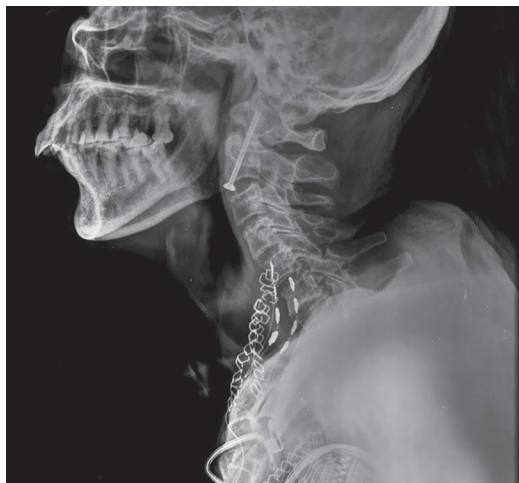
X-ray cervical spine lateral view showing ventral screw fixation of odontoid fracture and the electrodes placed over cervical part of phrenic nerve
